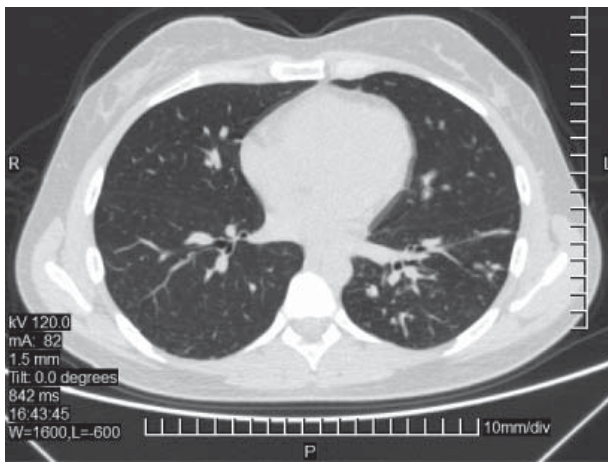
Chest CT scan of a patient with HIV status after 2 years of treatment. The appearance of focus and infiltrates in both lungs with a relapse of the tubercular process is noted
